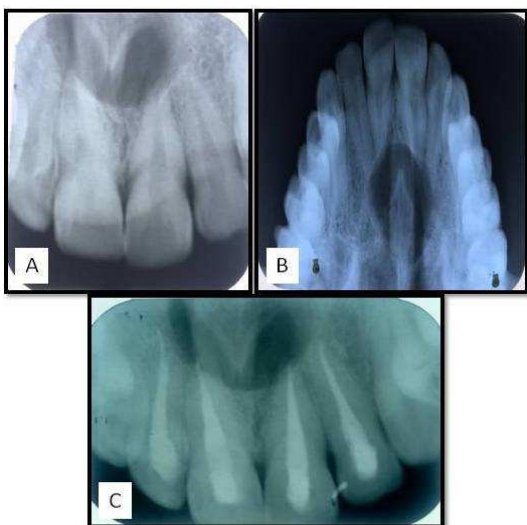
A- Intraoral Periapical Radiograph showing the lesion, B- Occlusal view showing the Pear Shaped Radiolucency, C- Root Canal treatment done.
